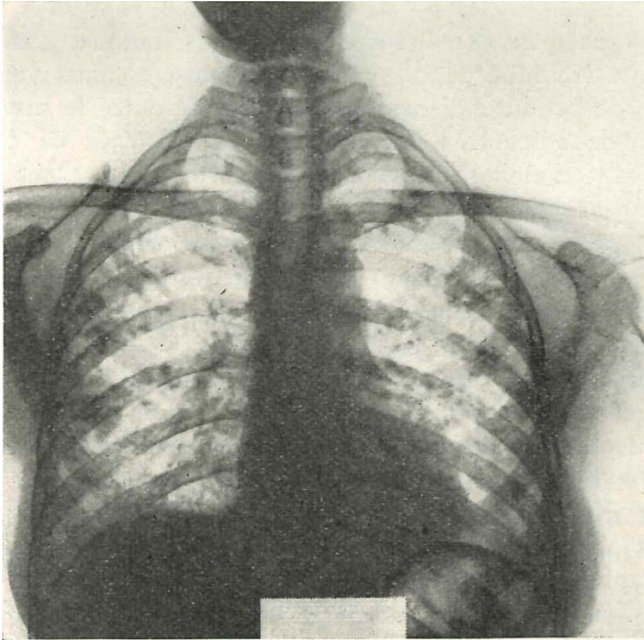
Chest radiography (positive image) of the first case described by Colinet with a typical “Caplan” pattern, i.e., multiple, well-defined, round opacities, particularly at the periphery (as published by his colleague Clerens in 1953).¹⁸
